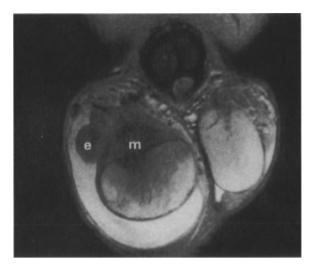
Scrotal lymphoma involving the right epididymis and testis is shown on a T2-weighted image. Note that the center of the mass (m) is in the epididymis (e) and infiltrates the testis from the hilum. The mass, located along the "bare area" of the testis, rotated the testis into a horizontal position. Note that the mass within the testis is patchy and its margins with normal testicular tissue are generally poorly defined. There is mild hypervascularity and moderate ipsilateral hydrocele. (MATTREY and TRAMBERT 1990)
